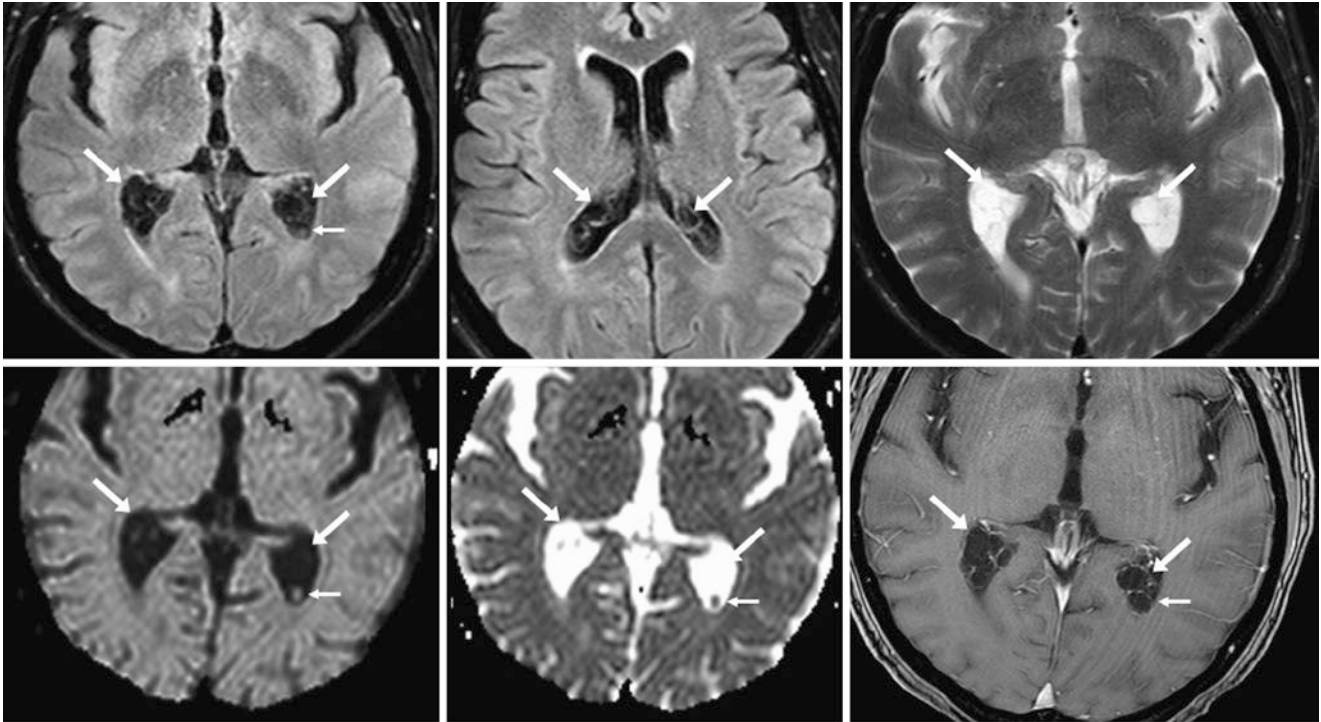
A 72-year-old patient underwent an MRI for stroke work-up (negative). Multiple, loculated, bilateral CPCs (*arrows*) are present within the atria of the lateral ventricles on axial FLAIR (*top left and middle*), T2WI (*top right*), and DWI (*bottom left*) with ADC map (*bottom middle*). Note the thin, enhancing rims of fibrovascular stroma on
